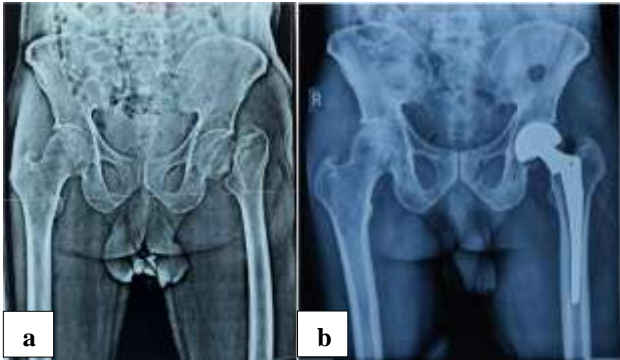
(a) Pre-operative X-ray, and (b) post-operative X-ray.
